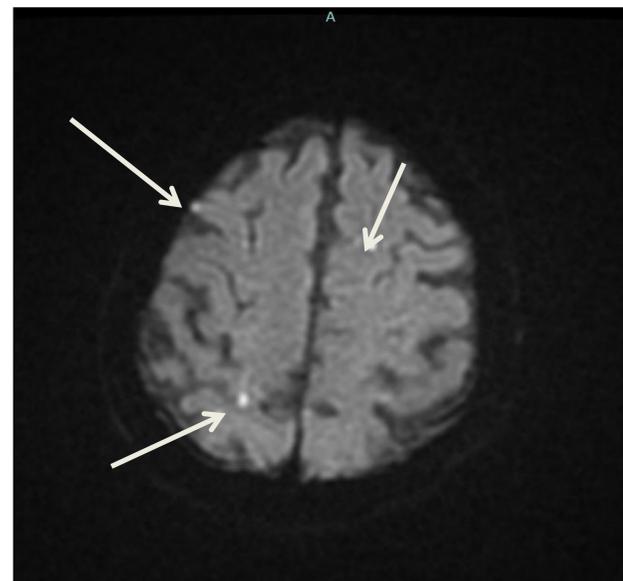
MRI of the brain showing septic emboli
